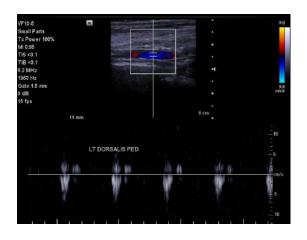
Picture showing identification of dorsalis pedis on colour/spectral sonography (left) and its occlusion on tourniquet inflation (right)
